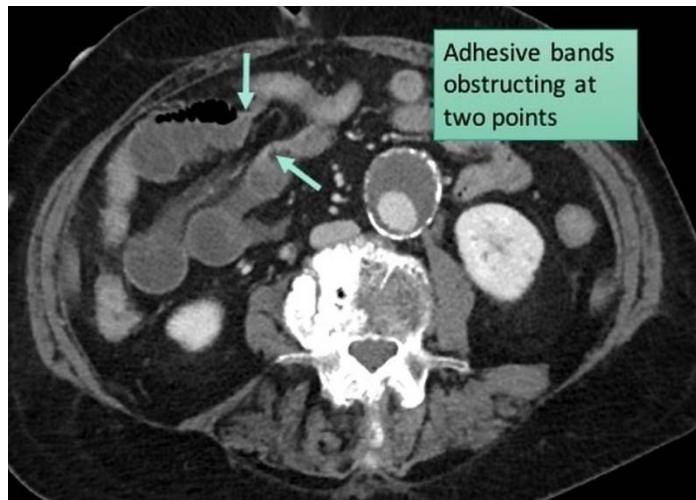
Axial abdominal CT of an adult patient showing closed-loop obstruction caused by adhesive bands[63]
